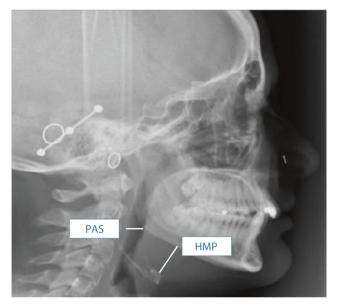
Cephalometric characteristics on lateral radiograph: Posterior airway space (PAS), hyoid to mandibular plane distance (HMP)
